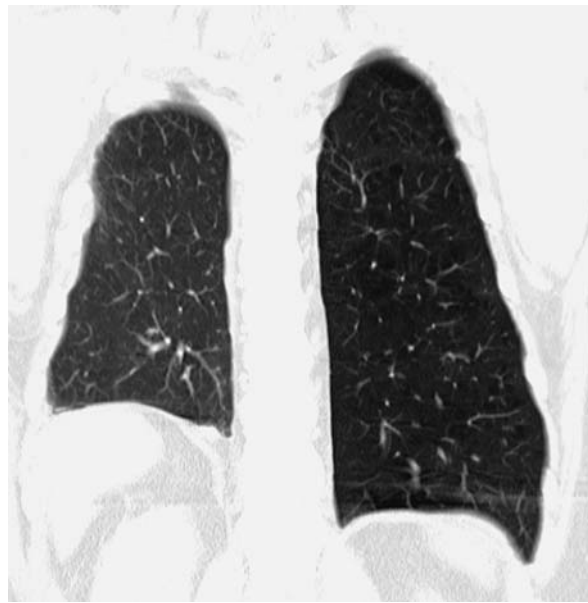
a Transverse CT section in a single-lung transplant recipient. Transplanted lung and native lung show marked differences in size and density. b Coronal multiplanar reconstructed CT section in a different single-lung transplant recipient as a. Transplanted lung and native lung show marked differences in size and density
